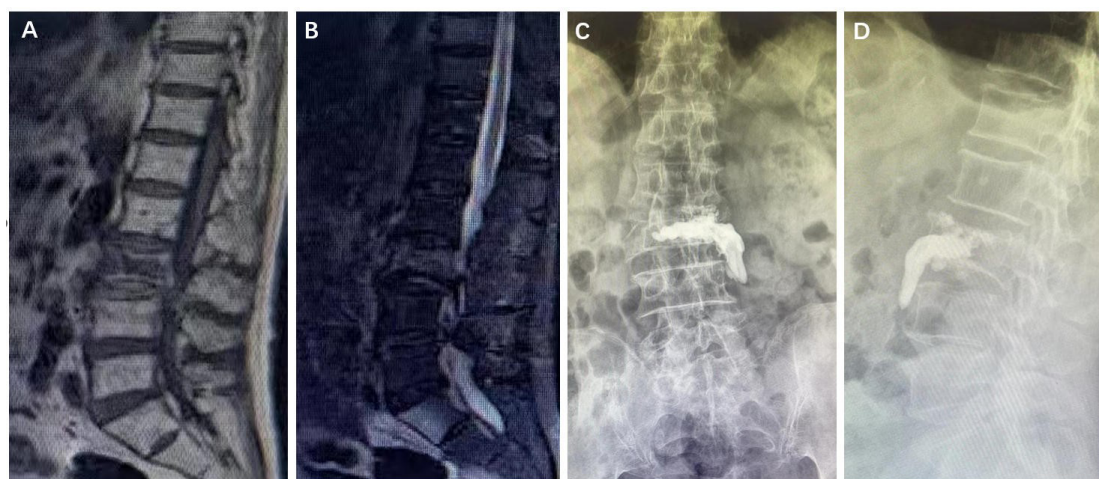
Inferior cement leakage following vertebral augmentation in a 71-year-old male with an osteoporotic L3 compression fracture. (A, B) Preoperative sagittal T2-weighted and fat-suppressed MRI demonstrating an acute compression fracture of L3. (C, D) Postoperative anteroposterior and lateral radiographs showing cement leakage extending inferiorly along the anterior margins of L3 and L4.
